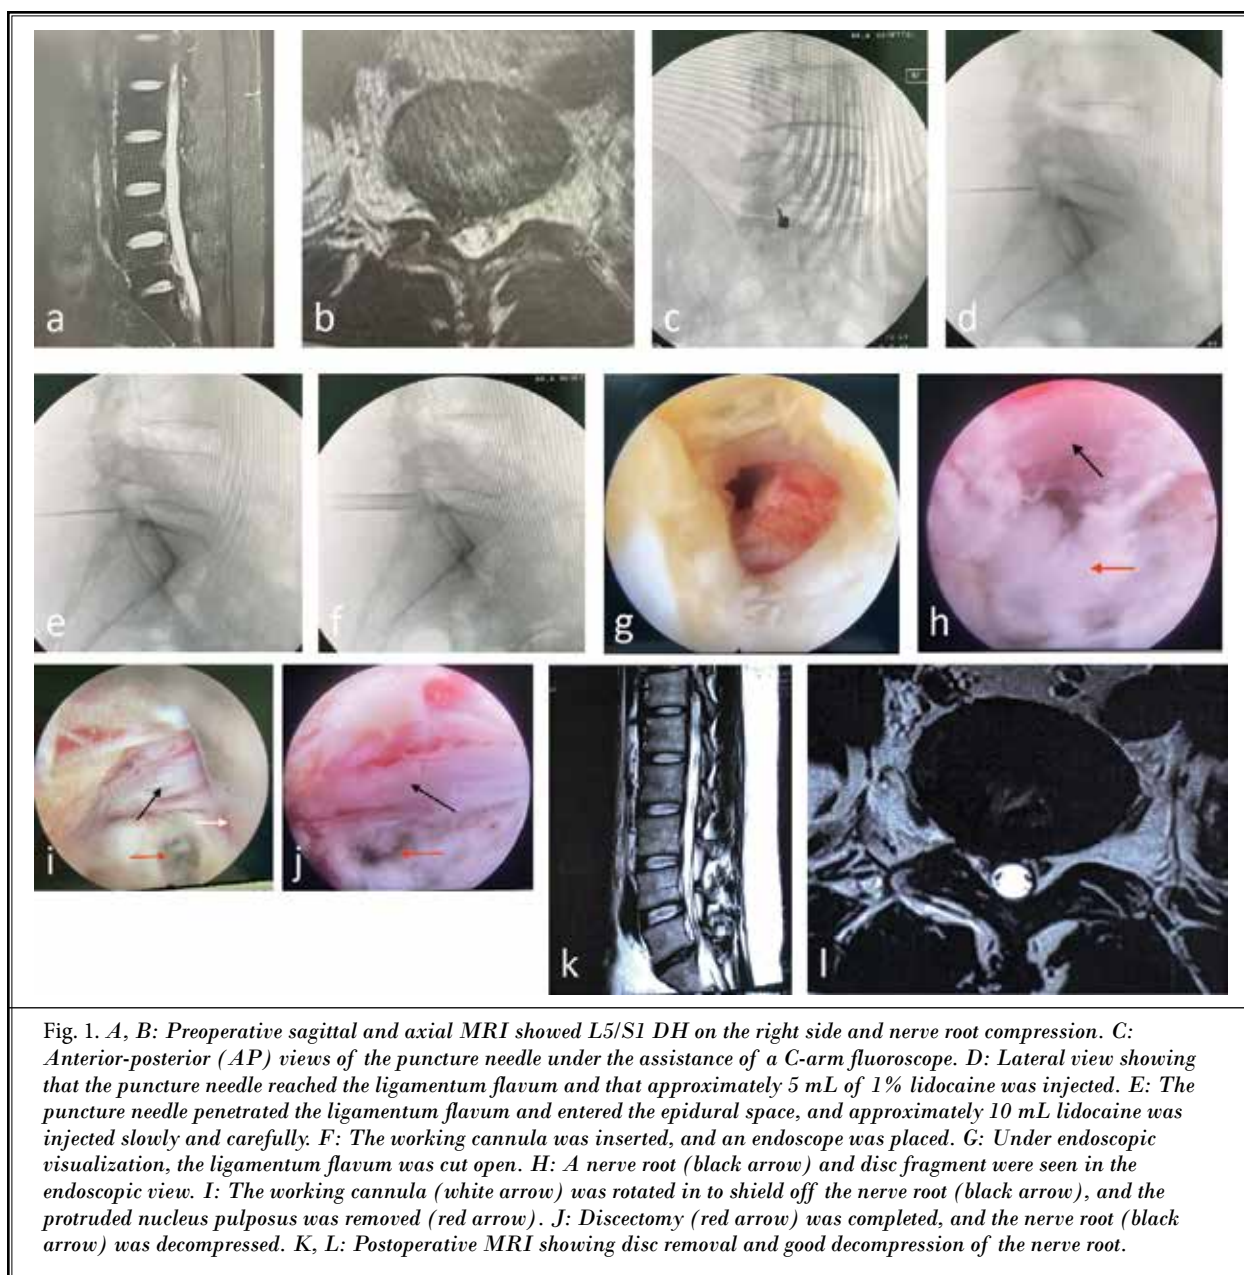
A, B: Preoperative sagittal and axial MRI showed L5/S1 DH on the right side and nerve root compression. C: Anterior-posterior (AP) views of the puncture needle under the assistance of a C-arm fluoroscope. D: Lateral view showing that the puncture needle reached the ligamentum flavum and that approximately 5 mL of 1% lidocaine was injected. E: The puncture needle penetrated the ligamentum flavum and entered the epidural space, and approximately 10 mL lidocaine was injected slowly and carefully. F: The working cannula was inserted, and an endoscope was placed. G: Under endoscopic visualization, the ligamentum flavum was cut open. H: A nerve root (black arrow) and disc fragment were seen in the endoscopic view. I: The working cannula (white arrow) was rotated in to shield off the nerve root (black arrow), and the protruded nucleus pulposus was removed (red arrow). J: Discectomy (red arrow) was completed, and the nerve root (black arrow) was decompressed. K, L: Postoperative MRI showing disc removal and good decompression of the nerve root.*
